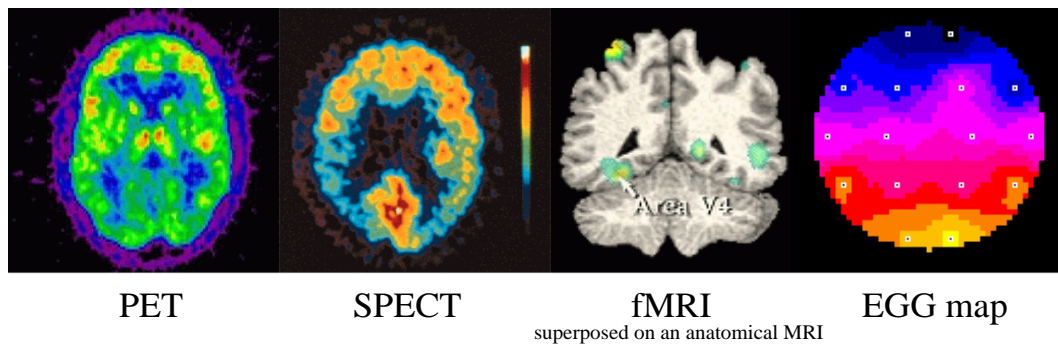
Functional Brain Images. SPECT is from <http://webnt.physics.ox.ac.uk>. EEG is from www.chasque.net.
